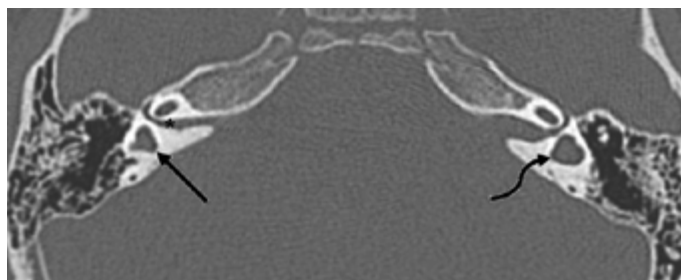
Axial CT image reveals fusion of the vestibule and LSC, forming a cystic lumen on the left side (curved arrow). On the contralateral side, there is both a narrow internal auditory canal and dysplastic vestibule-rudimentary LSC. CT: computed tomography; LSC: lateral semicircular canal
